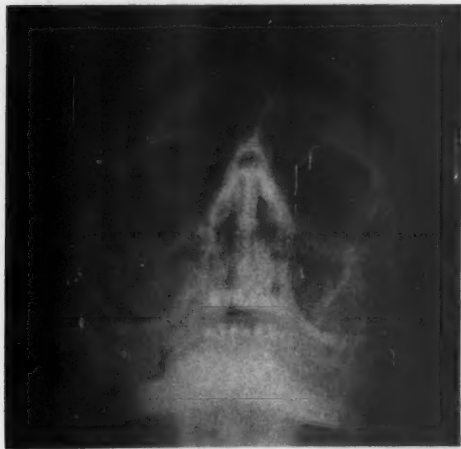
Case 3. Preoperative roentgenogram shows clearly the outward and downward displacement of the zygoma from its frontal attachment with increase in the diagonal diameter of the orbit.
